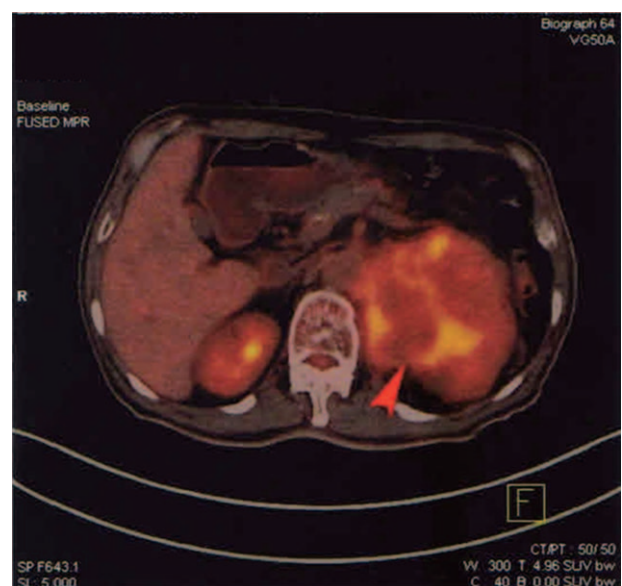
^{18}F -FDG imaging of the suprarenal mass. The tumor size is $9.8 \times 9.3 \times 10.8 \text{ cm}^3$. SUV max value is between 2.4 and 7.8, with an average between 2.1 and 6.9.
